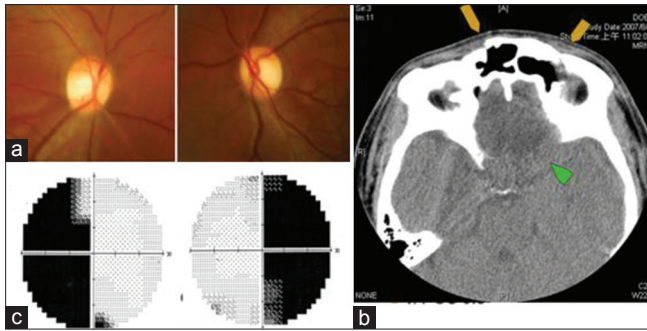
(a) Fundus examination revealed bilateral bow-tie shaped optic atrophy. (b) Computed tomography showed multiple skull bone fracture (yellow arrow) and encephalomalacia (green arrow). (c) Visual-field examination showed complete bitemporal hemianopia
